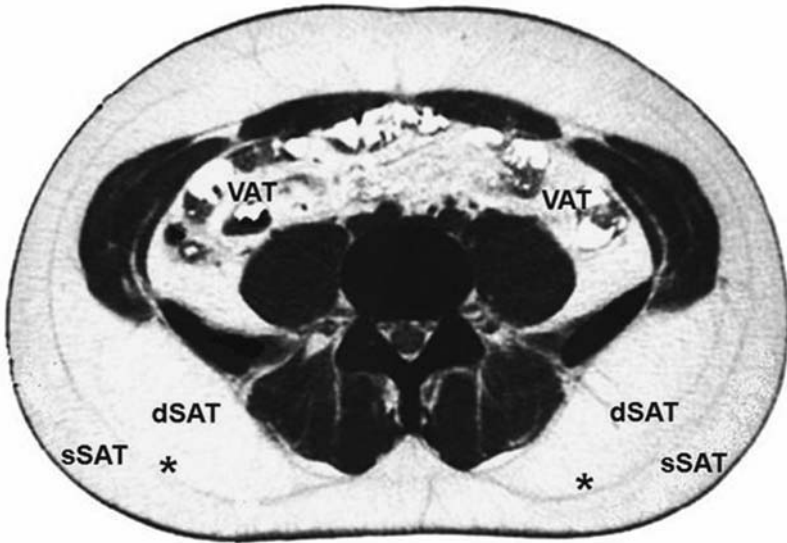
Computed tomography scan at abdominal level of obese subject. Visceral adipose tissue (VAT) and subcutaneous abdominal adipose tissue (SAT) with subtle fascial plane (asterisks) separating into superficial (sSAT) and deep (dSAT) portions. (Source: Modified from Iacobellis G, Corradi D, and Sharma AM. (2005). *Nat Clin Pract Cardiovasc Med* 2, 536–543.)
